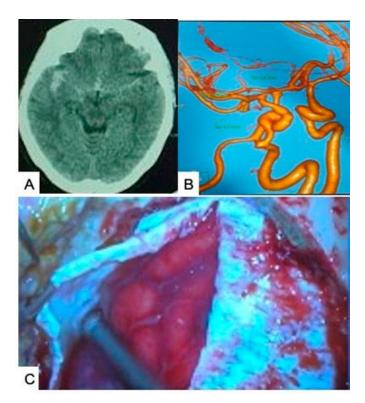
(A) CT scan showing an SAH likely from a ruptured right MCA aneurysm. (B) CTA showing a small right MCA aneurysm. (C) Blood in the subarachnoid space following an opening of the dura in an acute subarachnoid hemorrhage patient. Source: Figure by authors.
